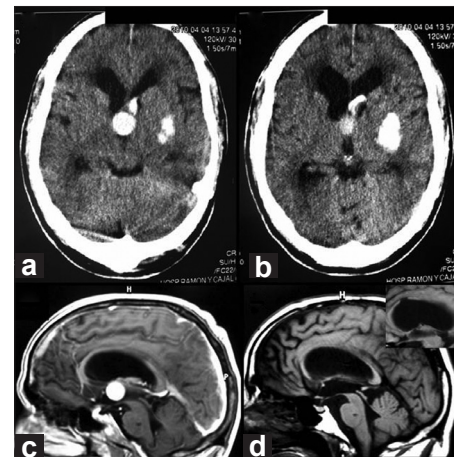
(a,b) Emergency brain CT displaying a left-sided putaminal hematoma of 9 cm³ and a rounded hyperdense lesion of 2.5 cm in its major diameter, located at the anterior third ventricle, which causes acute biventricular hydrocephalus. There are signs of intraventricular bleeding in contact with the outer border of the lesion at the left foramen of Monro. (c) Brain T1-weighted Gadolinium-enhanced MRI. This parasagittal slice shows a homogeneous hyperintense rounded lesion in the anterosuperior part of the third ventricle. (d) Postoperative mid-sagittal slice of a T1-weighted MRI showing no signs of residual tumor at the third ventricular chamber. The inset in the upper right corner corresponds to a right parasagittal slice displaying the small callosal section performed during the surgical approach
